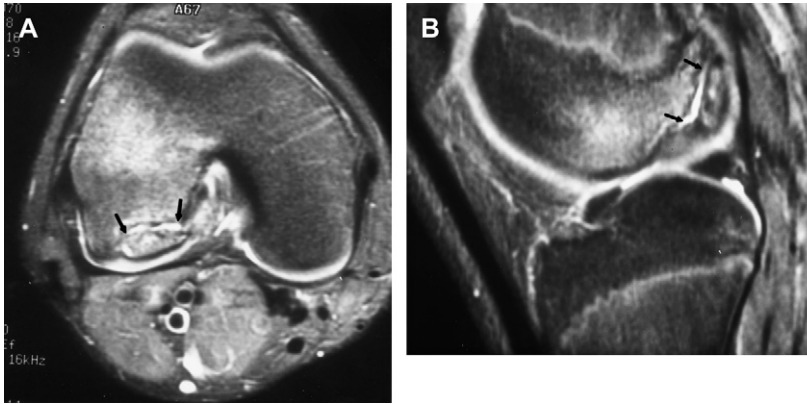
Grade 4 OCD. Axial (A) and sagittal (B) T2-weighted images demonstrate fluid signal intensity (arrows) between the osteochondral lesion and the femur. Slight displacement of the fragment is also shown.
